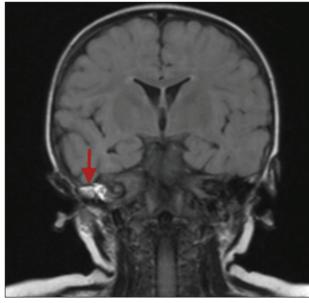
MRI scan of a child who presented with a right LMN facial nerve palsy showing right petrous apex metastatic neuroblastoma (arrow).*
